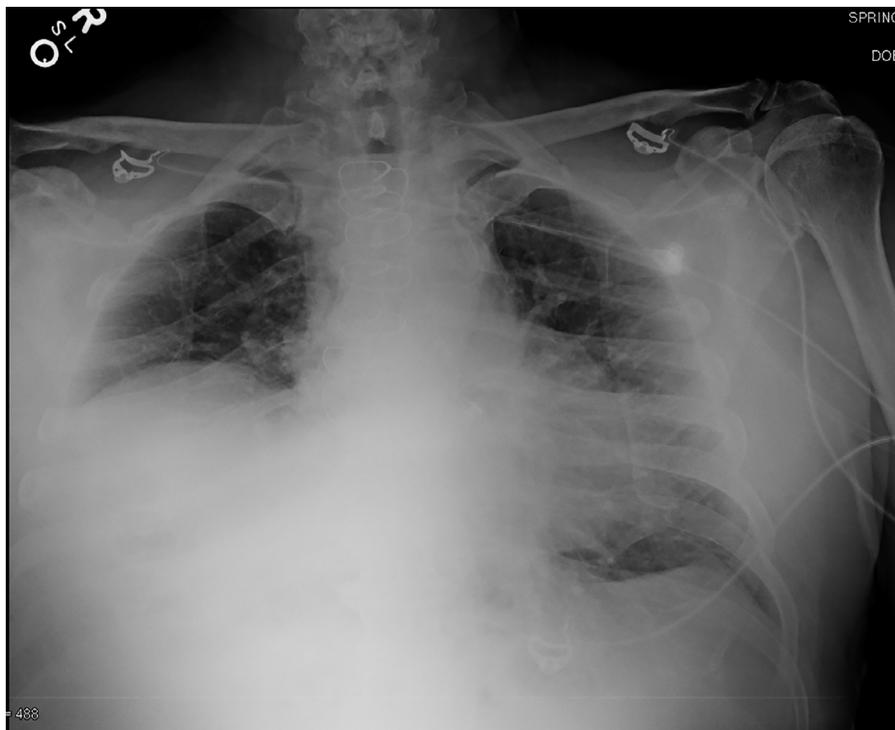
Portable chest X-ray demonstrating marked elevation of the right hemi-diaphragm, consistent with phrenic nerve palsy.
